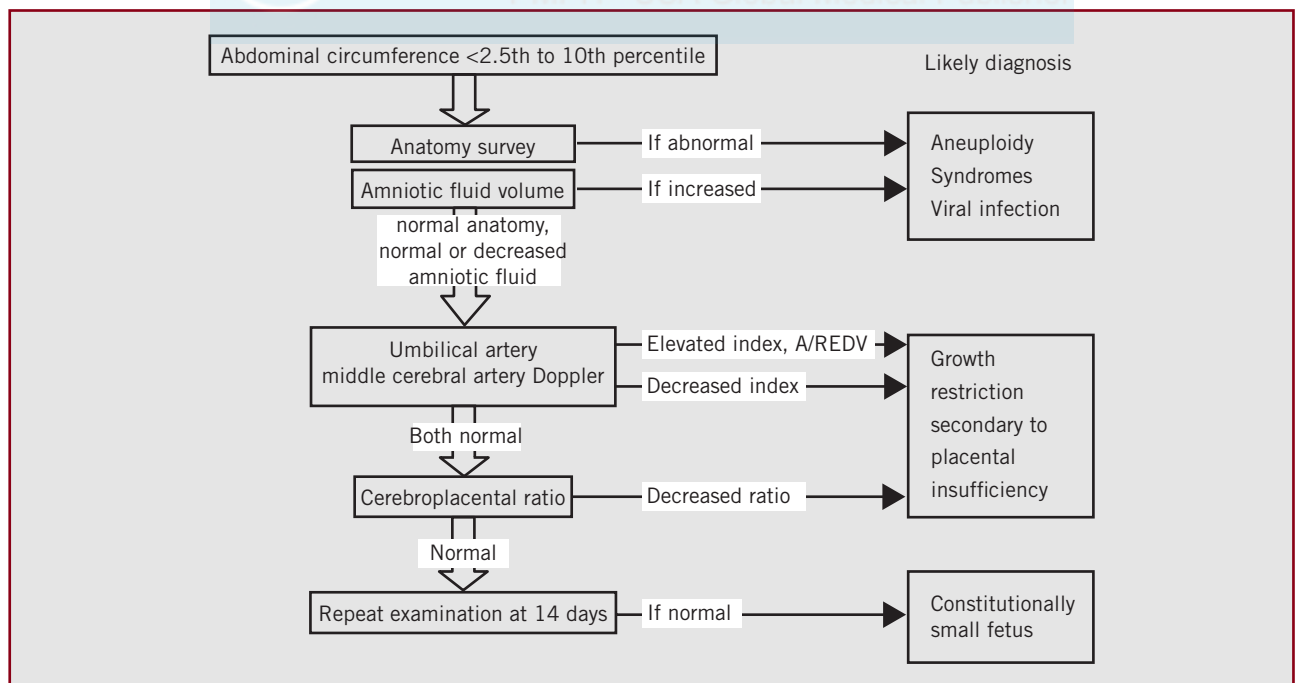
This figure displays a decision tree following the evaluation of fetal anatomy, amniotic fluid volume, and umbilical and middle cerebral artery Dopplers. The most likely clinical diagnosis is presented on the right hand side. A high index of suspicion for aneuploidy, viral and non-aneuploid syndrome needs to be maintained. IUGR=intrauterine growth restriction. (Figure 4 in Baschat AA. Pathophysiology of fetal growth restriction-implications for diagnosis and surveillance. *Obstet Gynecol Survey* 2004; 59:617–27.)
